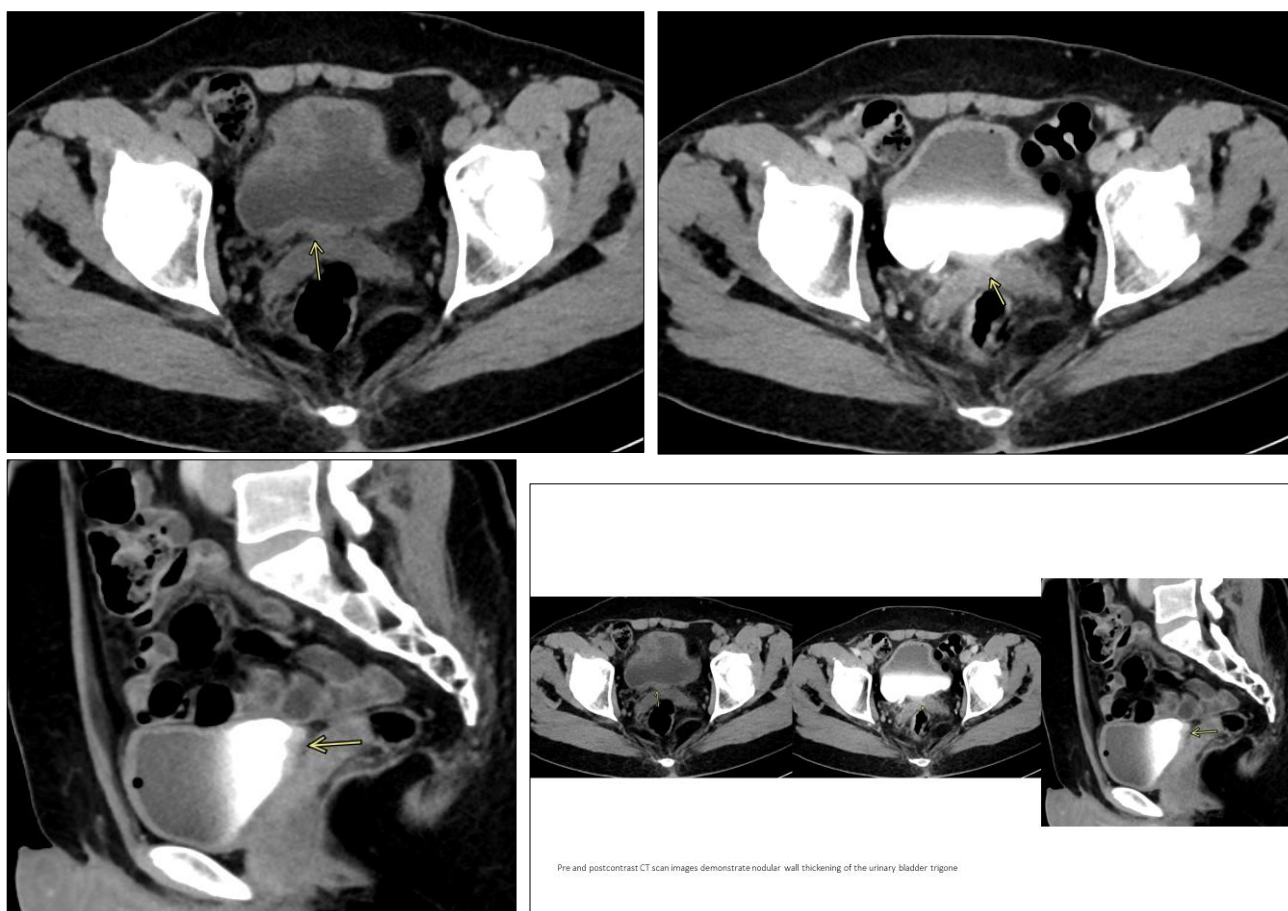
Pre and postcontrast CT scan images from the patient's initial assessment demonstrate nodular wall thickening of the urinary bladder trigone
